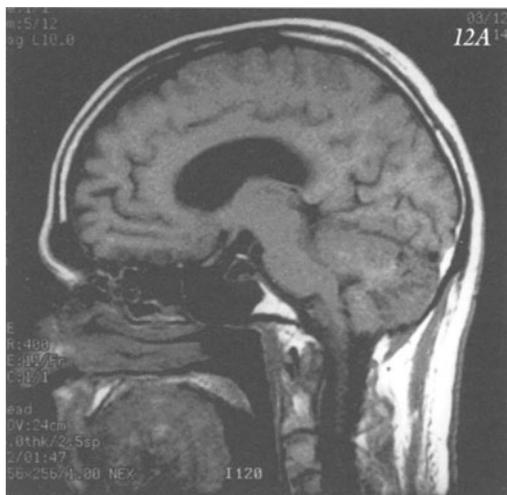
Cerebellar infarct in posterior inferior cerebellar artery territory. Case 20-6. Refer to text. MRI: A) T1 weighted sagittal section 10 mm to left of midline. B) T2 weighted posterior coronal section. C) T2 weighted axial sections at level of upper medulla inferior olive.
